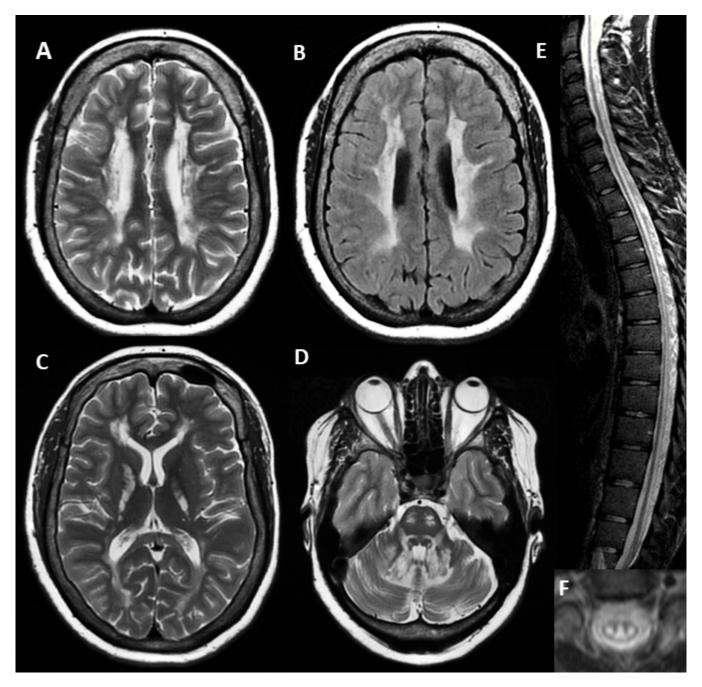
T₂-weighted (A, C, D) and FLAIR (B) axial images of the brain in an adult with LBSL show extensive, patchy abnormalities with increased signal in the periventricular and deep cerebral white matter and posterior limb of the internal capsule. In the posterior fossa the superior cerebellar peduncles, the intraparenchymal trajectories of the trigeminal nerves, the pyramidal tracts, and medial lemniscus in the pons are affected (D). T₂-weighted spinal cord images (E, F) show increased signal over the entire length of the spinal cord (E) with involvement of the (lateral) corticospinal tracts and dorsal columns (F).
